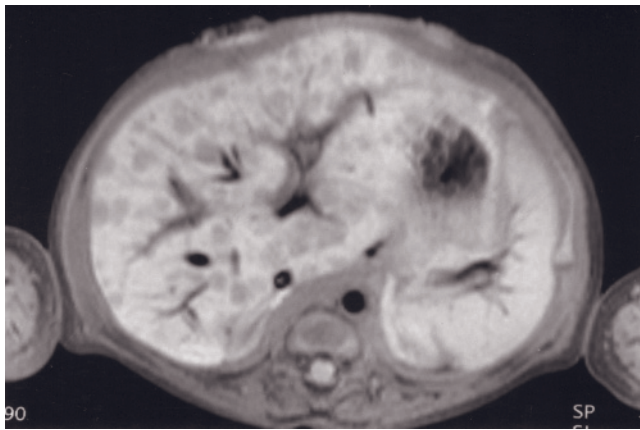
Infantile hemangioendothelioma. T2-weighted fat-suppressed ETSE (a), T1-weighted fat-suppressed SE (b), and T1-weighted interstitial-phase fat-suppressed gadolinium-enhanced SE (c) images. The liver in this 9-month-old boy is extensively replaced with focal mass lesions, smaller than 1 cm, that are high in signal intensity on the T2-weighted image (a) and mildly low in signal intensity on the T1-weighted image (b) and enhance homogeneously on the interstitial-phase gadolinium-enhanced image (c). This appearance is characteristic for hemangioendothelioma in neonatal patients.
